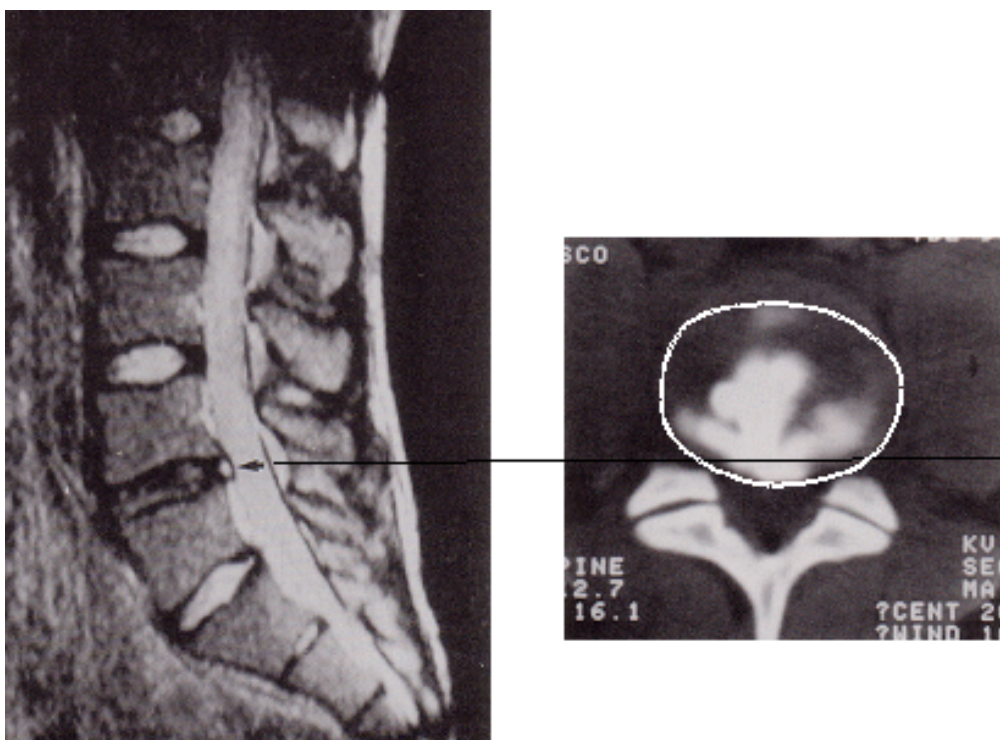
The anatomy of high intensity zones (HIZ). The HIZ seen on sagittal MRI of an L4 disc (arrowhead) constitutes a sagittal section of the transversely widest length of a circumferential fissure, as shown in the CT discogram.
